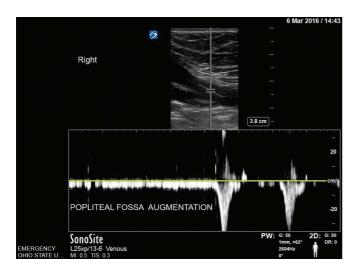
Popliteal vein augmentation using pulsed-wave Doppler.
